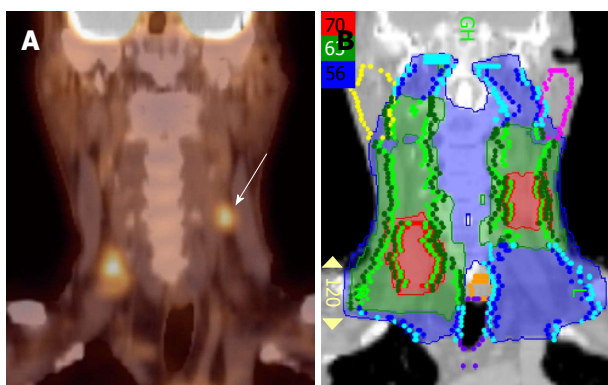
Positron emission tomography/computed tomography extends the high dose CTV contralaterally in a patient with a T2N2B base of tongue cancer. A: PET/CT reveals a contralateral level III node (white arrow), and thus, the patient was upstaged as T2N2C; B: An IMRT plan of this patient showing that this node was treated to 70 Gy and contralateral levels II and III were treated to 63 Gy. IMRT: Intensity modulated radiation therapy; PET/CT: Positron emission tomography/computed tomography.
